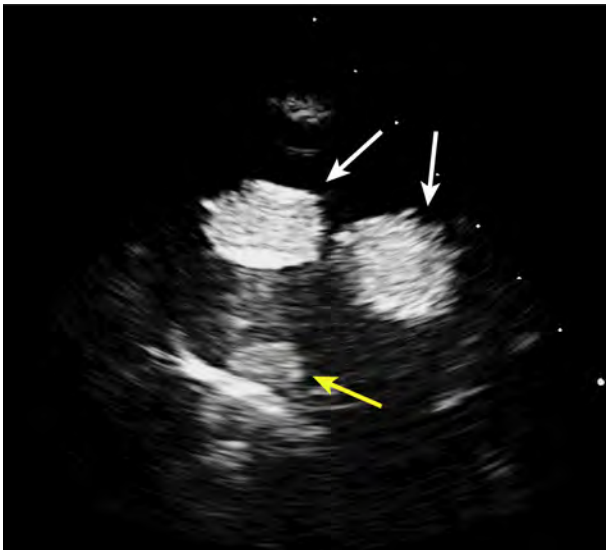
Short-axis view of the iliac bifurcation (*white arrows*) in a 74-year-old man status post aortic stent grafting for an abdominal aortic aneurysm. Ultrasound contrast agent-enhanced images demonstrate a type 2 endoleak (*yellow arrow*) located inferiorly and posteriorly at the graft bifurcation. The remainder of the aneurysm sac appears filled with organized thrombus. See [Video 14](#), available at www.onlinejase.com.
